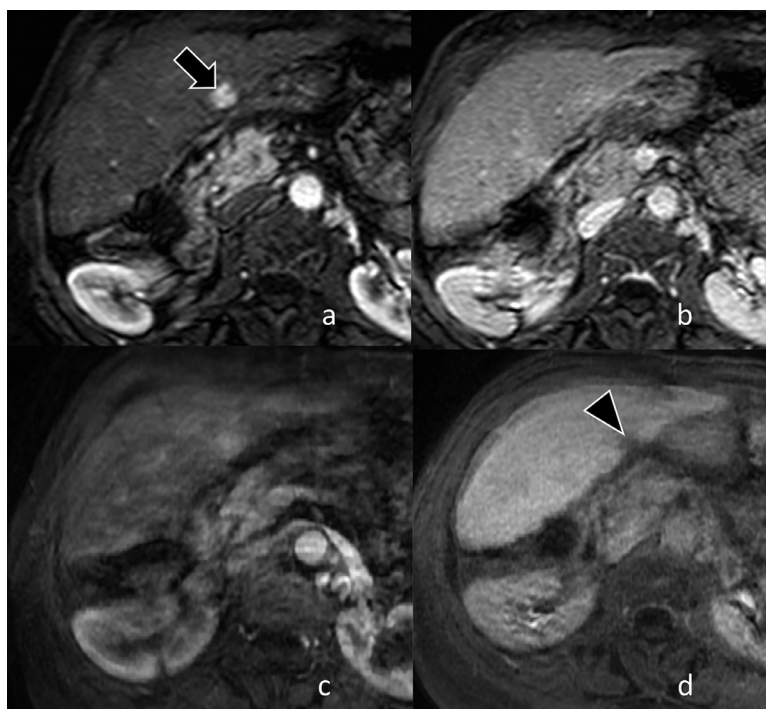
MR imaging exams performed with gadobenate dimeglumine (a, b) and gadoxetic acid (c, d) in an 83-year-old woman with HCV cirrhosis. The flash-filling hemangioma in this patient shows homogeneous enhancement (arrow) in the arterial phase with both gadobenate dimeglumine (a) and gadoxetic acid (c) enhanced MR imaging exams. The hemangioma is slightly hyperintense to the liver in the 3-minute phase with gadobenate dimeglumine (b), and hypointense (arrowhead) in the 3-minute phase with gadoxetic acid (d). The “pseudo washout” sign in this hemangioma refers to the arterial phase hyperenhancement followed by the lower signal intensity of the hemangioma compared to the surrounding hepatic parenchyma in the 3-minute phase. HCV, hepatitis C virus; MR, magnetic resonance.
